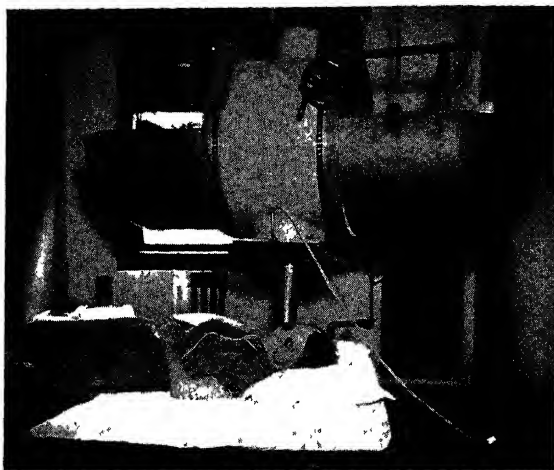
Case of carcinoma of antrum being treated through a metal cone, 7 cm. in diameter. (Martin and McNattin. Am J Roentgen)
